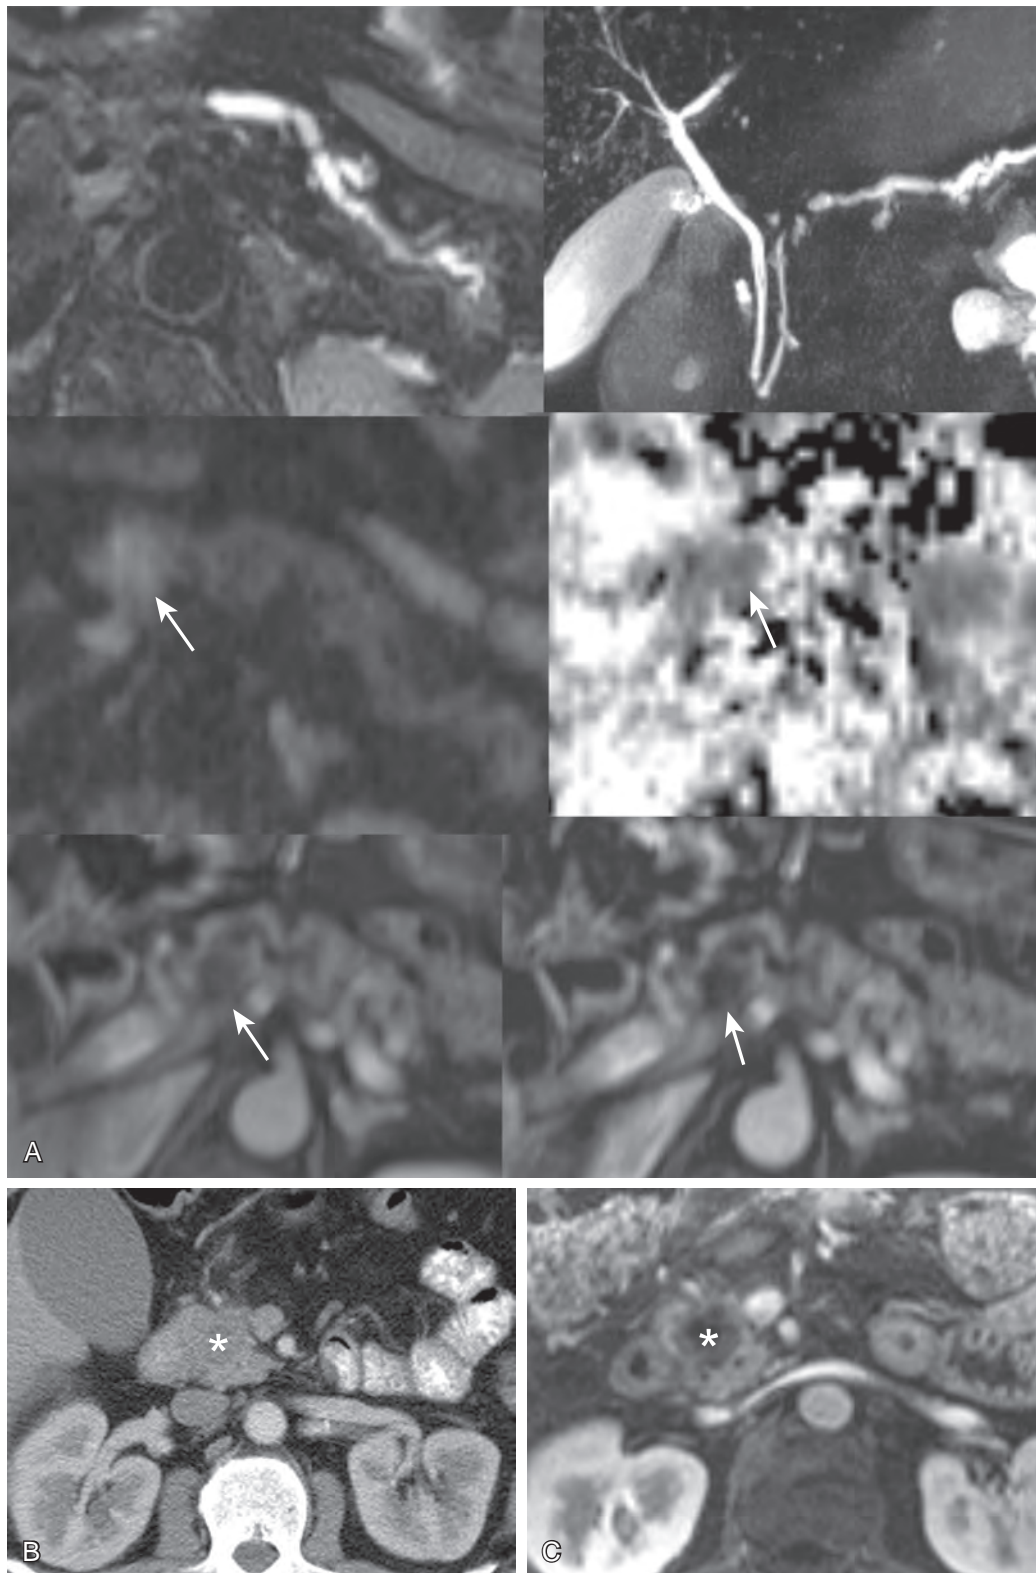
Pancreatic adenocarcinoma. A. MRI evaluation of a 68-year-old woman. *Top row:* Fat-saturated T2 sequence (left) and long T2 slab MRCP (right) reveal segmental main pancreatic duct dilation. *Middle row:* High b value diffusion-weighted image (left) shows restriction with high signal in region of change in duct caliber (arrow). Corresponding apparent diffusion coefficient map shows decrease in region of interest (arrow). This combination is characteristic of neoplasm. *Bottom row:* Image from gadolinium-enhanced gradient recalled echo sequence (left) reveals focal low signal mass at point of caliber change in pancreatic duct (arrow). Contrast is increased by use of subtraction imaging (right). B. Adenocarcinoma, head of pancreas, in a 52-year-old man. An infiltrating mass (asterisk) in the head of the pancreas is seen on pancreatic phase MDCT. C. Adenocarcinoma, head of pancreas; same patient as in B. The mass (asterisk) is more clearly delineated on the gadolinium-enhanced gradient recalled echo T1-weighted sequence. Radiation therapists find MR useful for more precise definition of tumor margins, resulting in better targeting.
